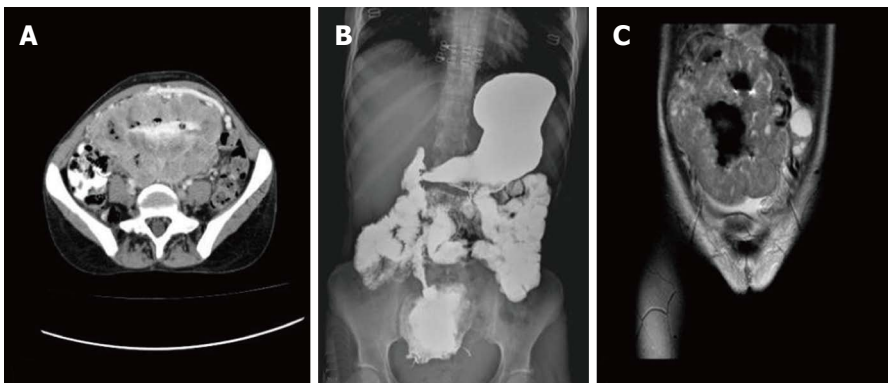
Results of image. A: Computed tomography scan: oral and IV contrast revealed a large thick wall cavity mass (17 cm × 11 cm) with the enhancing wall; B: Barium follow-through delineated a large cavity connected to a segment of small bowel located at the mid-pelvic region; C: Magnetic resonance imaging of T1 and T2 coronal image shows a large cavity lesion containing gas and fluids and connected to a segment of small bowel but not related to the ovaries.
